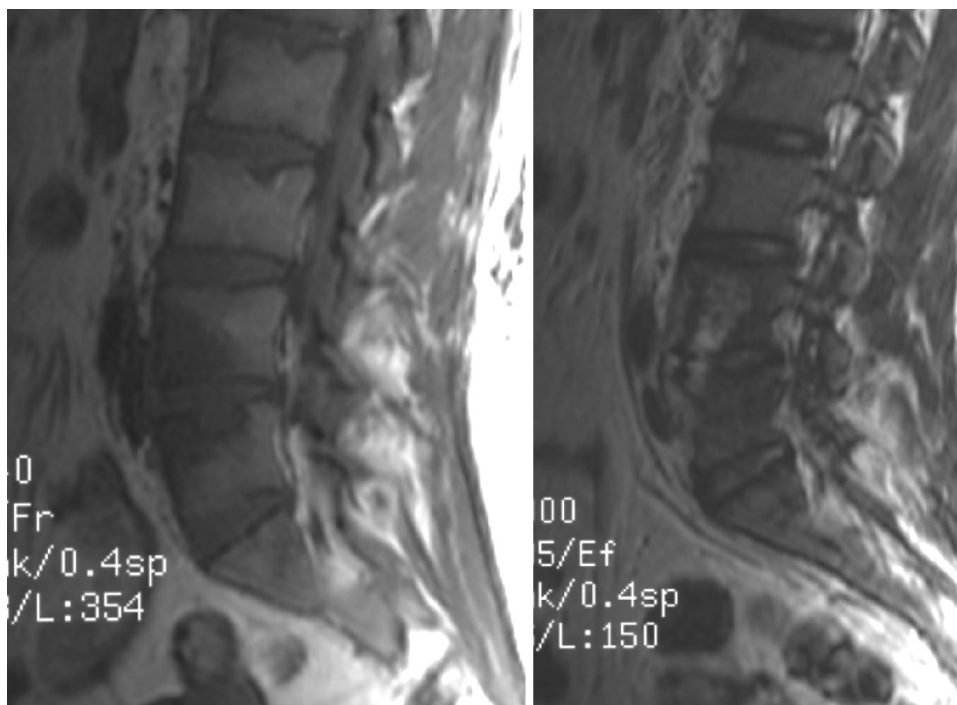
Magnetic resonance imaging scan of the lumbar spine revealed an increased signal at position L4-L5.
